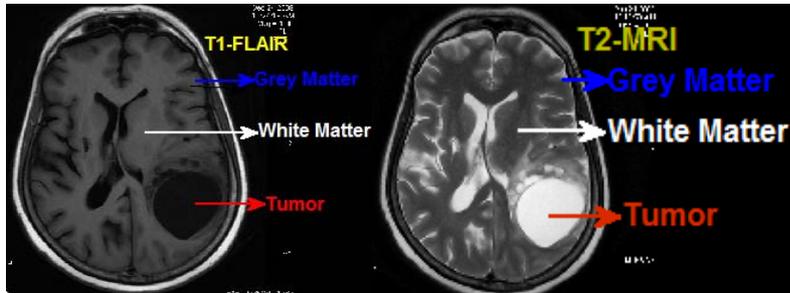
18 Sample raw data from a patient volume used segmentation. T1-FLAIR and T2-weighted MRI slice
